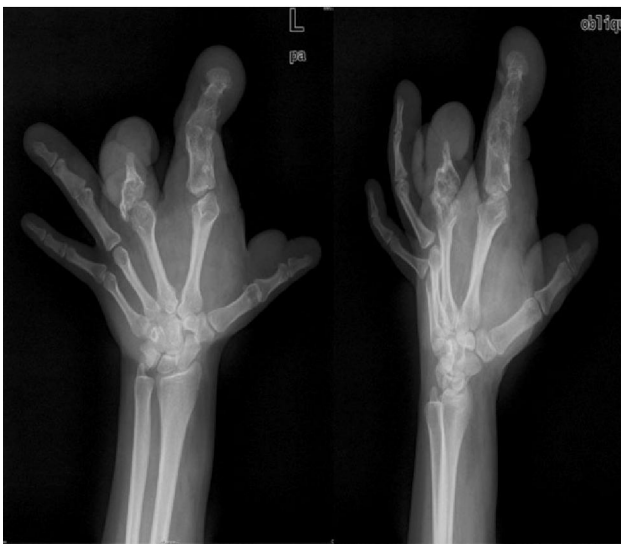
X-rays of left hand. Enlarged and deformed fingers and diffuse soft tissue swelling of hand. Evidence of previous surgery in middle finger.
